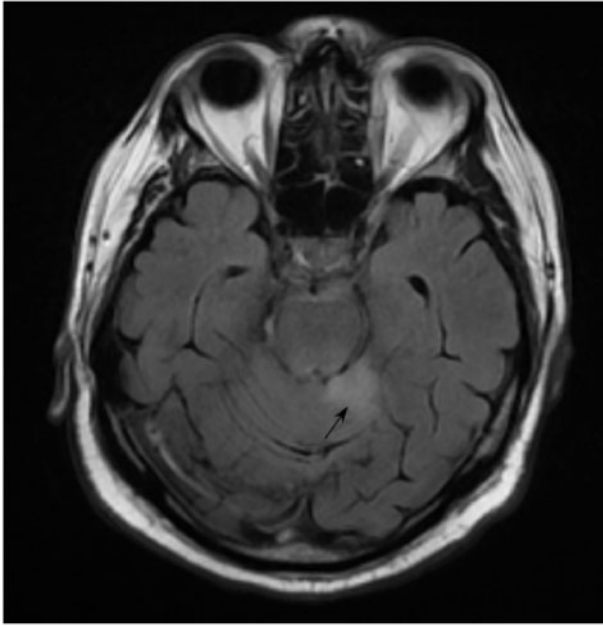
Magnetic resonance imaging of the brain (T2 FLAIR) demonstrated ischaemic changes in the cerebellar hemispheres.
